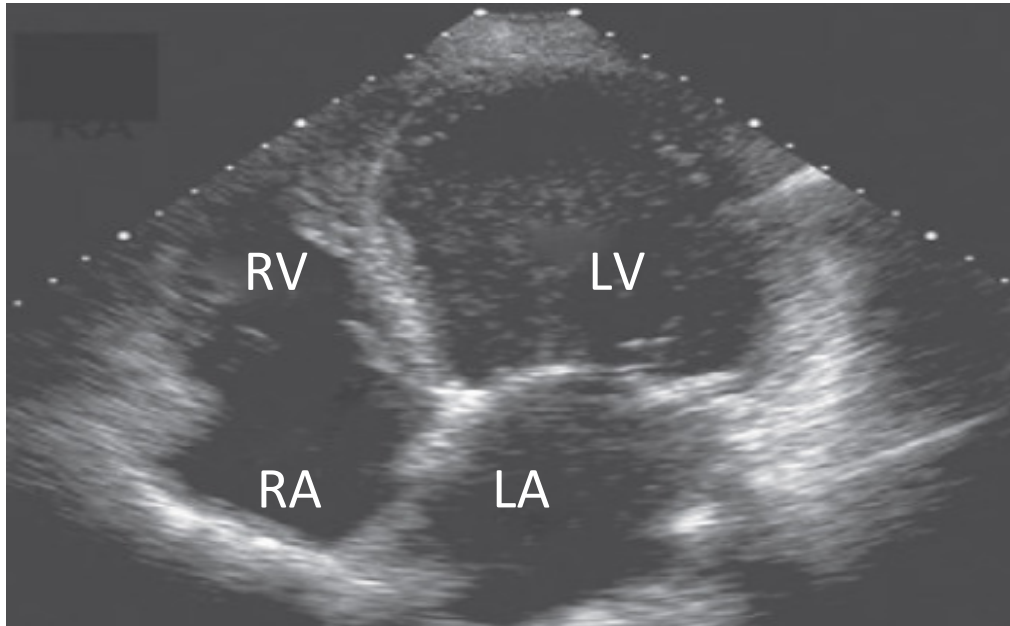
Two-dimensional echocardiogram (parasternal four chamber) showing a dilated, thinned left ventricle (LV).
